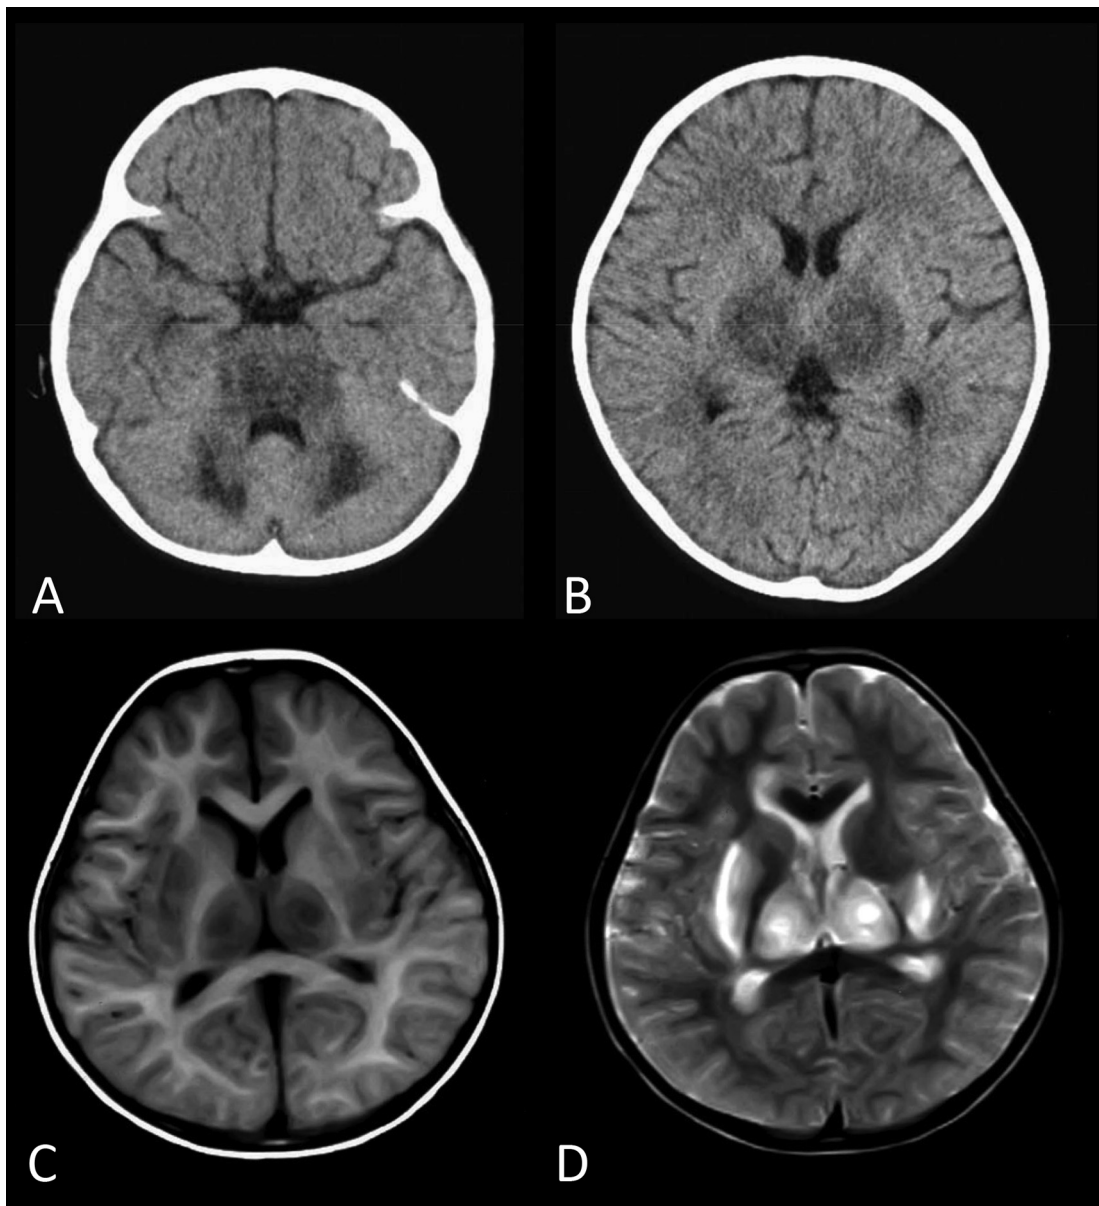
CT and MRI findings of acute necrotizing encephalopathy (ANE). A and B: CT findings. Symmetrical low densities are observed in the bilateral thalamus, dorsal pons and cerebellar white matter. C and D: MRI findings. Lesions showing low intensities on T1-weighted images and high intensities on T2-weighted images are seen in the bilateral thalami, periventricular white matter and external capsule.
